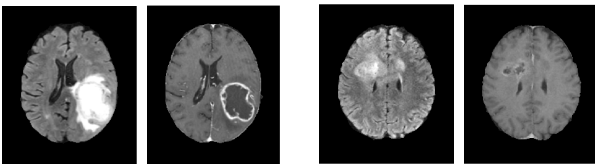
Example of variability in tumor appearance. It shows two pairs of images (FLAIR and T1Gd), with the first pair containing an enormous and very expressive tumor and the second with a small and discrete.
